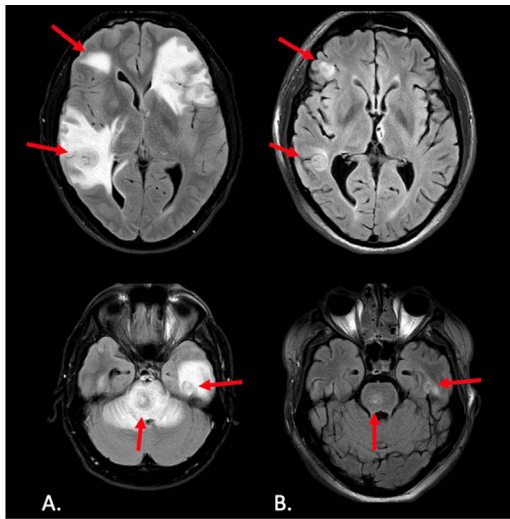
Axial sections of pre- and post-treatment T2 FLAIR MRI demonstrating a decrease in size of the intracranial lesions (red arrows), as well as a significant decrease in the surrounding edema. Column A is the pre-treatment MRI, and column B is the post-treatment MRI.
